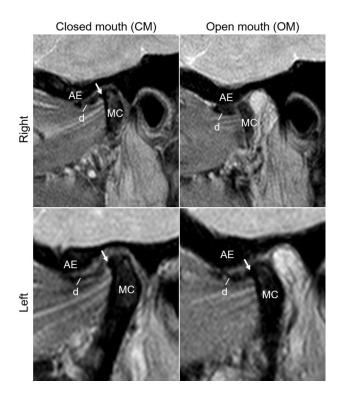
Sagittal proton density weighted magnetic resonance images in open and closed mouth positions of the temporomandibular joint (TMJ). On the closed mouth (CM) view of the right TMJ, the disc is located anteriorly to the mandibular condyle; the open mouth (OM) image shows there is no reduction of the disc displacement. The CM and OM views of the left TMJ also shows anterior disc displacement without reduction. The white arrows point to osteophytes. AE: articular eminence; D: articular disc; MC: mandibular condyle.
